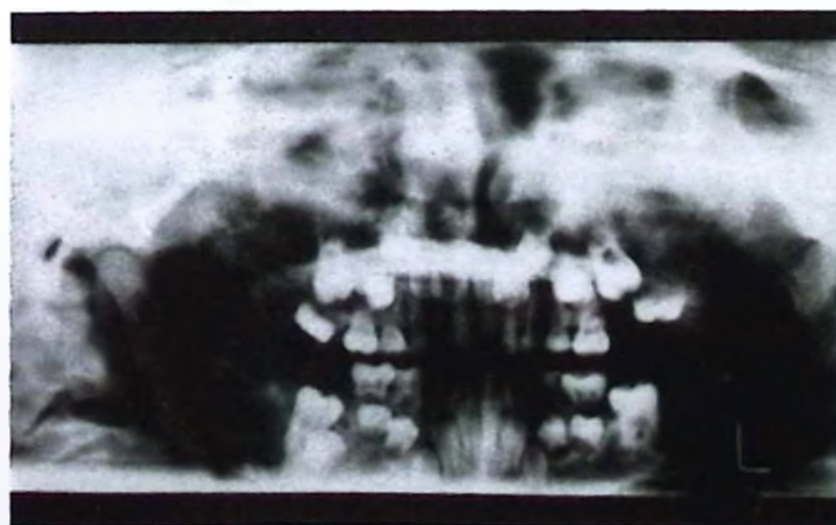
The panoramic mandibular x-ray of the patient. The status of the teeth is typical.
